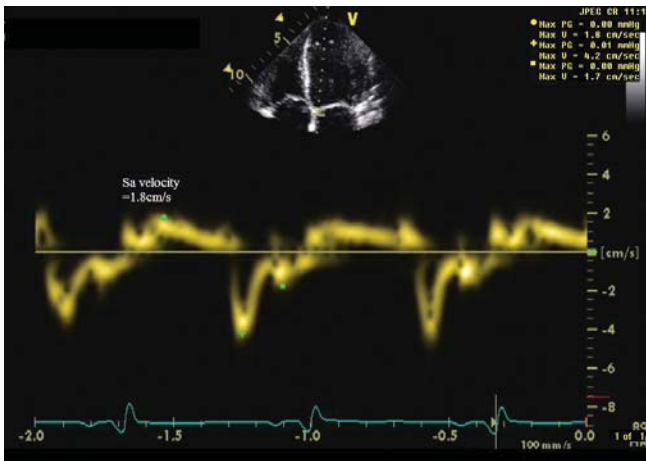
Pulse tissue Doppler imaging from the septal mitral annulus in a patient with ischaemic cardiomyopathy. Note the significant decrease in Sa velocity correlating with the systolic dysfunction.
